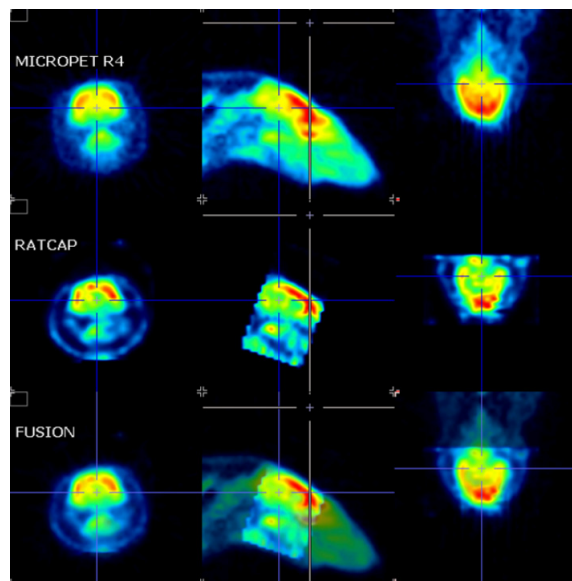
Quantitative comparison of RatCAP and microPET R4 images using ^{18}F -FDG. Note that the RatCAP covers only 2 cm of the microPET's axial FOV. The jagged edges are due to rotation during coregistration.
